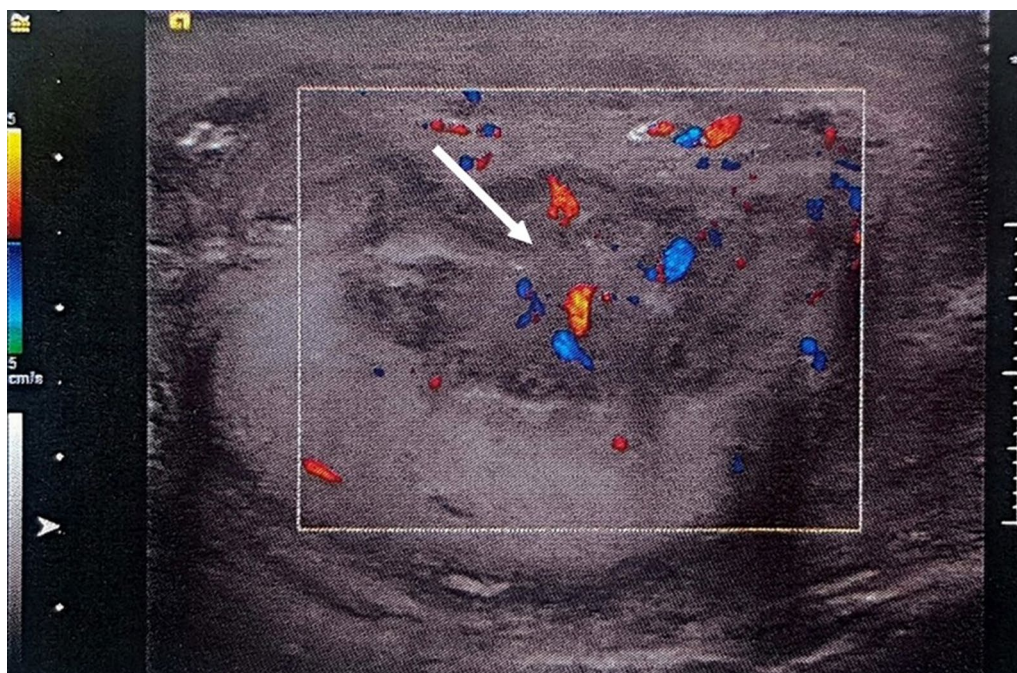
Color Doppler image showing internal vascularity of the testicular mass
